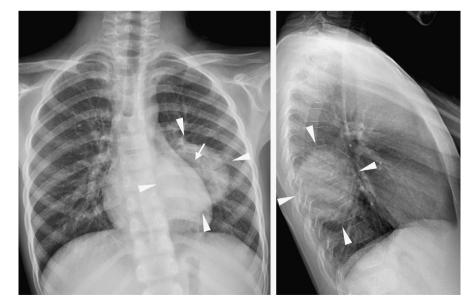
Chest X-rays at presentation showed a well-demarcated round opacity in the left lower lung field (arrowheads). Note the apparent air bronchogram on the posteroanterior view (arrow).
